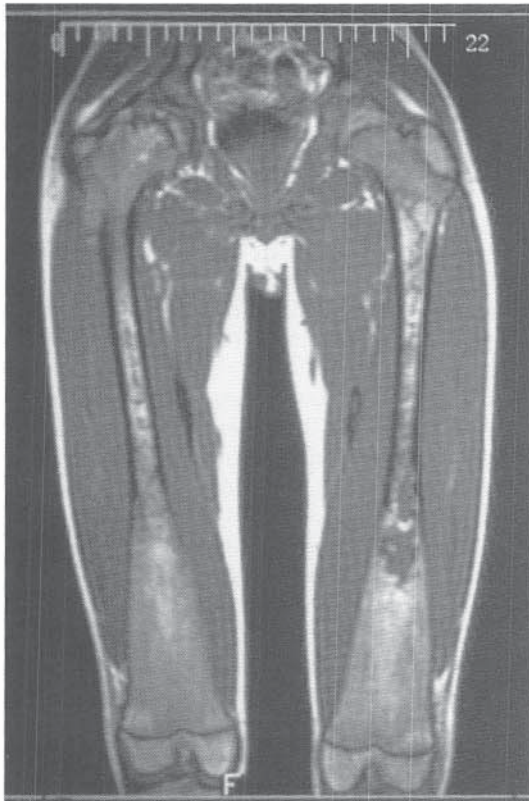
T1-weighted image in a 13-year-old boy with Gaucher's disease showing bilateral avascular necrosis of the hips and Erlenmeyer flask deformities of the distal femora. Abnormal regions of decreased signal intensity intermixed with regions of fatty marrow (bright signal) are seen in the proximal and midfemora, representing marrow replacement.
